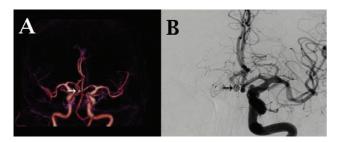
Three-dimensional angio-computed tomography image and threedimensional reconstruction that evidences aneurysmal disease at the level of AComA. (A, *left*) Aneurysm in anterior communicating segment (*arrow*). (B, *right*) Postoperative embolization with AComA aneurysm coils (*arrow*).
